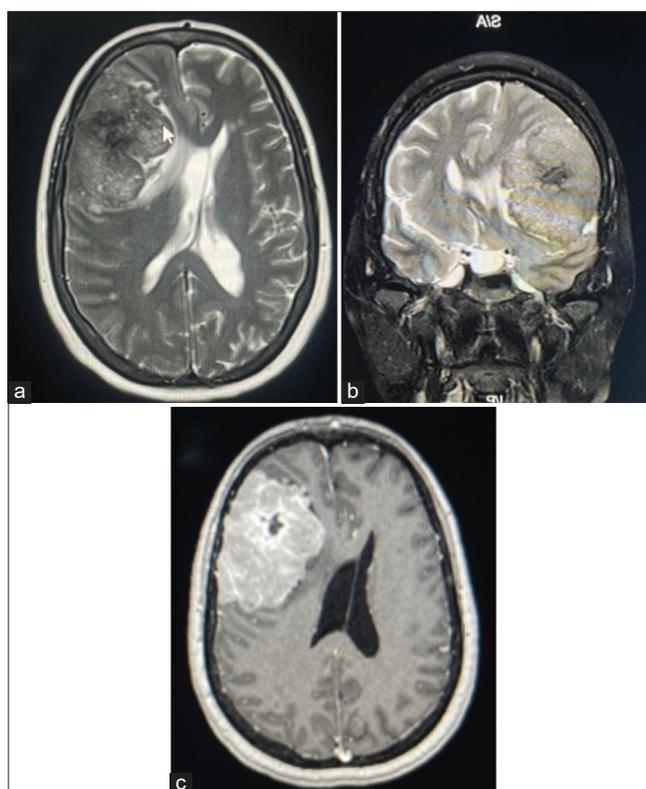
Case 3: (a) Axial T2-weighted brain magnetic resonance imaging (MRI), (b) coronal T2-weighted brain MRI, (c) Axial T1-weighted brain MRI. Type 1 Nauta classification
